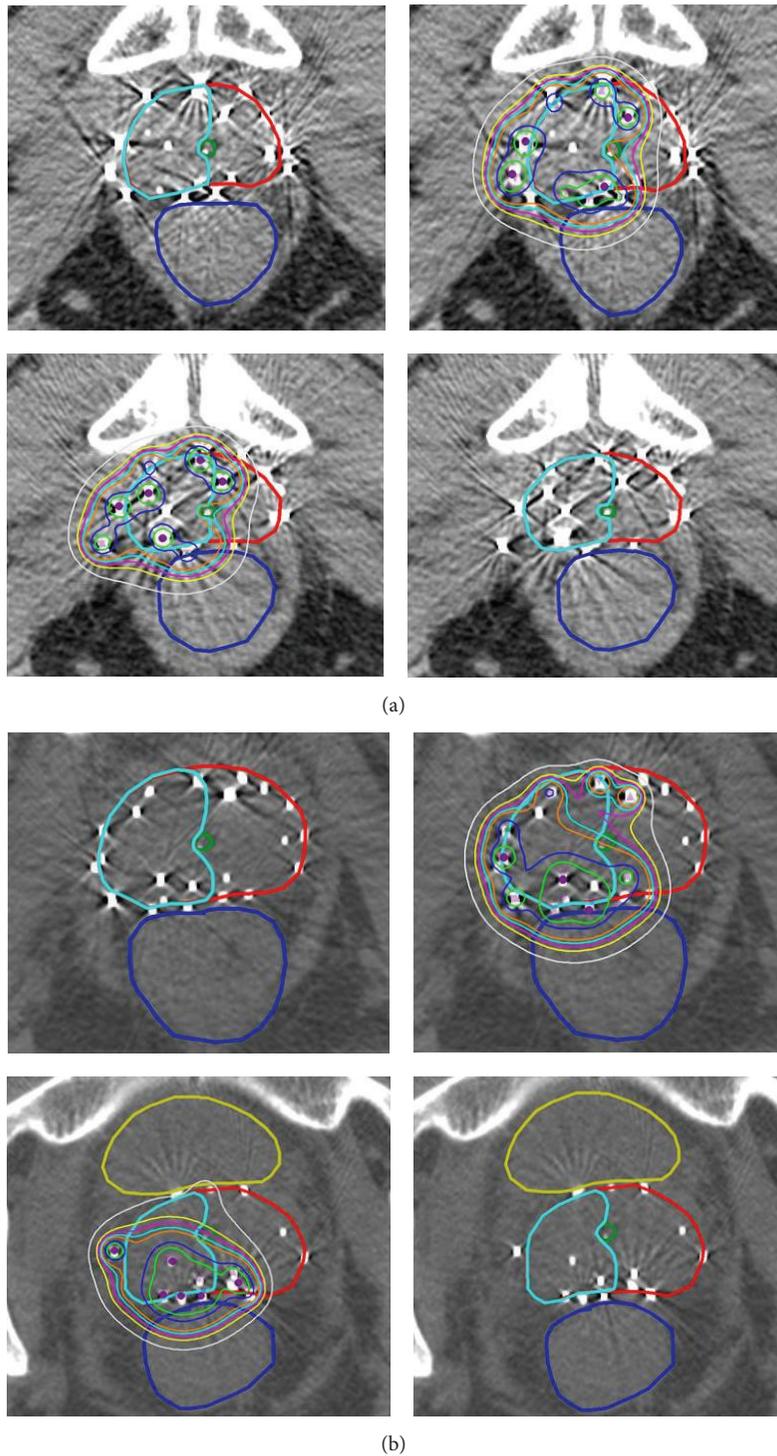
(a) Sample brachytherapy planning scans using BrachyVision software. (b) CT images showing seed distribution after reimplantation with and without reimplant isodose distributions.
